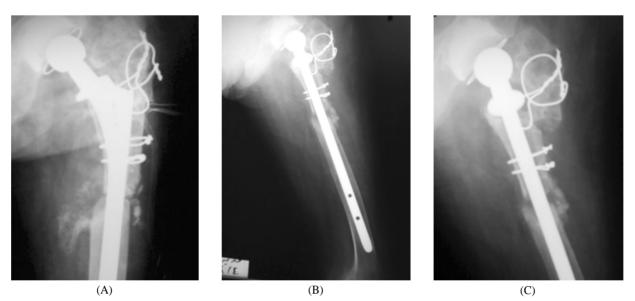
(A) Anteroposterior radiograph hip and upper femur postoperative 6 months. (B) Anteroposterior radiograph hip and upper femur postoperative 12 months. (C) Lateral radiograph hip and upper femur postoperative 12 months.
